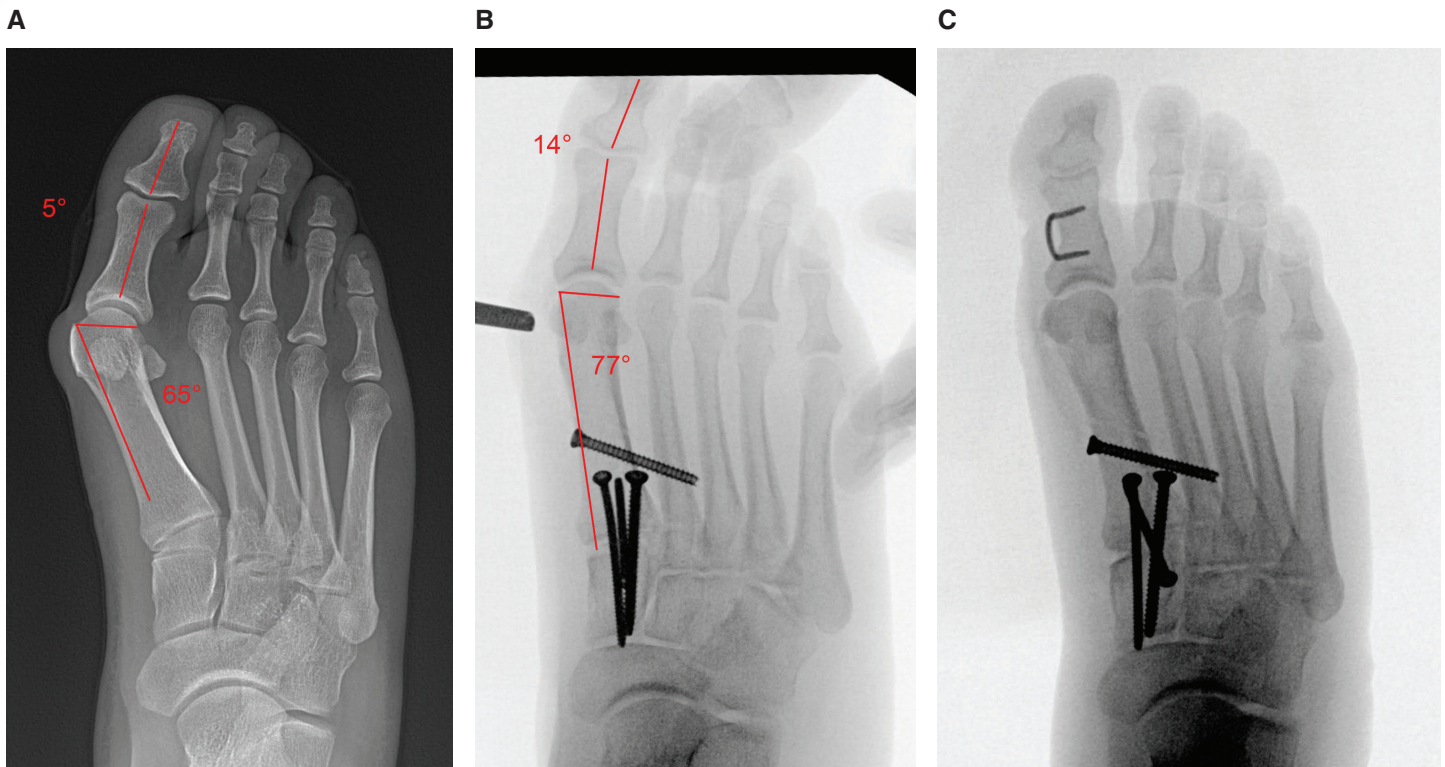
(A) Preoperative standing AP radiograph of 18-year-old male with symptomatic hallux valgus. The DMAA is 25 degrees and interphalangeal angle between the proximal and distal phalanx is 5 degrees. (B) Intra-operative evaluation of the DMAA and interphalangeal angle after correction and fixation with a Lapidus procedure. Note that the DMAA is now 13 degrees, so the decision was made to perform a distal soft tissue realignment rather than a distal osteotomy. However, the interphalangeal angle now measures 14 degrees. (C) Intra-operative radiograph after performance of a proximal phalanx medial closing wedge osteotomy.
